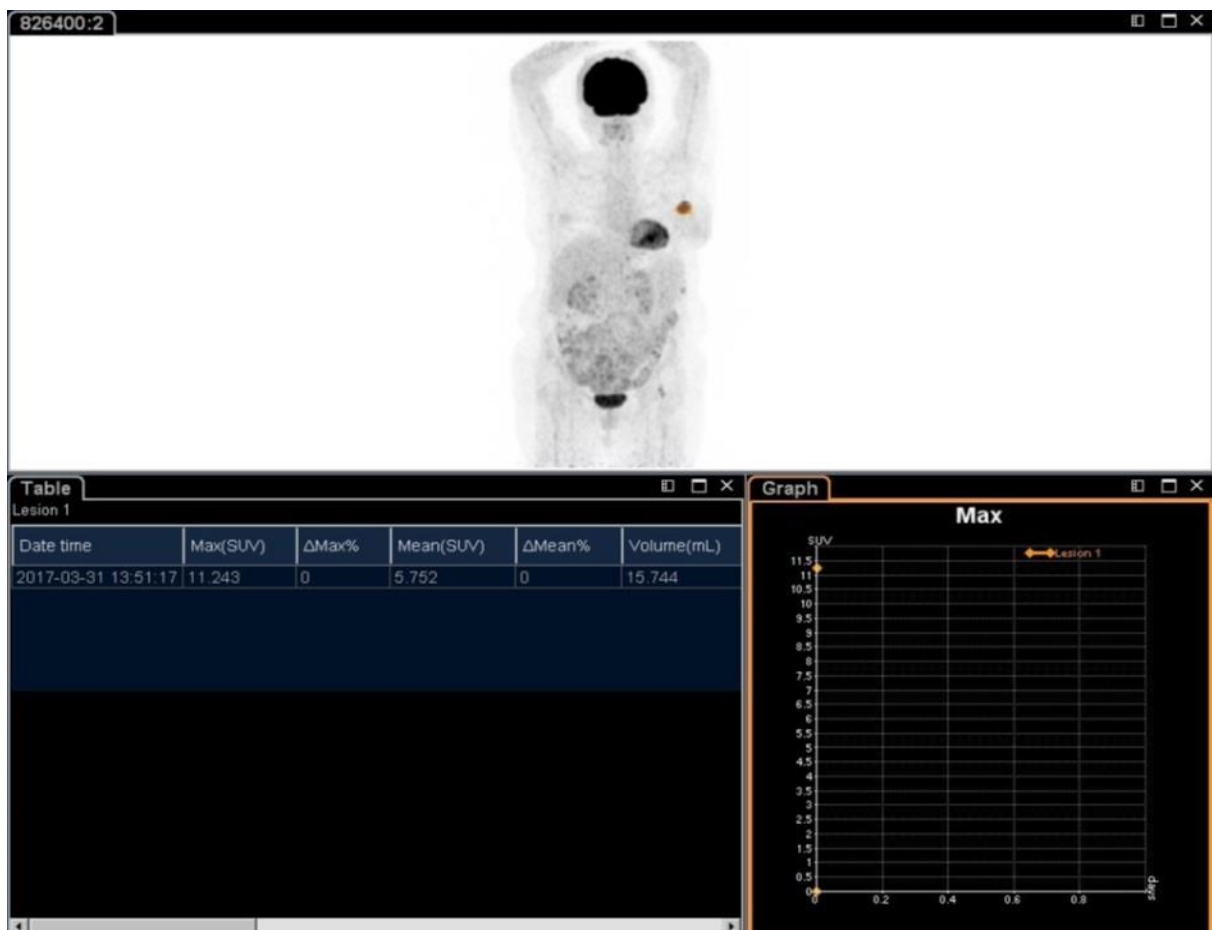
Calculation of SUVmax values by tumour tracking method
